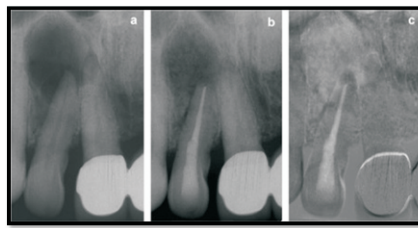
Digital Radiograph (a) pre-operative, (b) post-operative (c) Root filling and healing zone are emphasized in lighter shades of grey by using Digital subtraction radiography (Image from Ingle's 6th edition)
